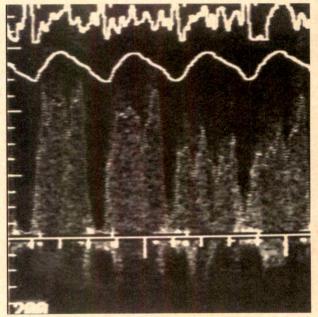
Doppler flow velocity signals at baseline (left) and during adenosine-induced hyperemia (right). The smaller systolic flow integral (gray area) begins immediately after the R wave and the larger diastolic flow velocity integral begins at the aortic pressure dicrotic notch. The peak diastolic velocity and average peak velocity (APV) demonstrate a near doubling with coronary hyperemia. Velocity scale is 0-200 cm/sec. DSVR = diastolic/systolic velocity ratio.
